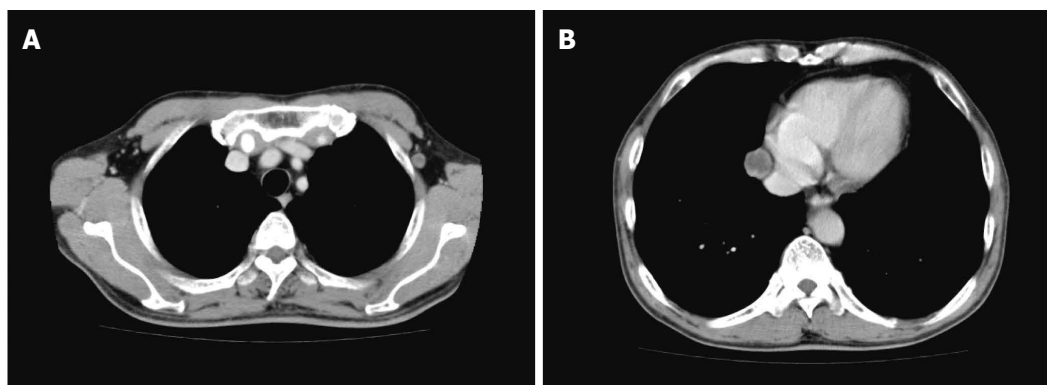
Computed tomography reveals a tumor in the left axilla (A, diameter: 1 cm) and a tumor in the right mediastinum (B, diameter: 2 cm).
